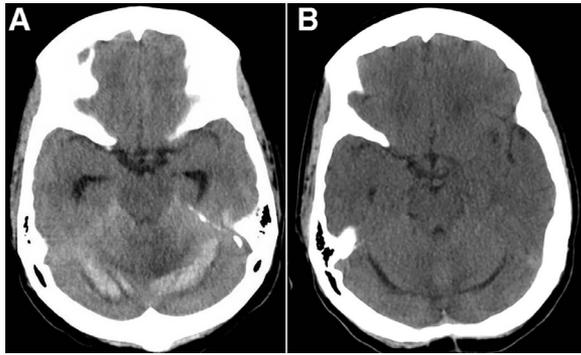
(A) Noncontrast computed tomography (CT) of the brain demonstrates bilateral hyperdensities in the rostral cerebellum with so-called “zebra sign” evident on the right side. Dilated temporal horns of the lateral ventricles with effacement of the fourth ventricle without overt brainstem compression are also demonstrated, indicative of developing obstructive hydrocephalus. (B) Follow-up CT of the brain demonstrating resolution of cerebellar hemorrhage with loss of cerebellar tissue and resolution of hydrocephalus.
